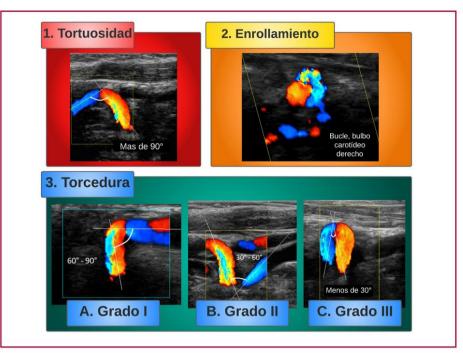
Images of different types of carotid dolichoarteriopathies obtained with color Doppler echocardiography. The angle between each part of the artery is drawn with white lines and described in the corresponding image.
